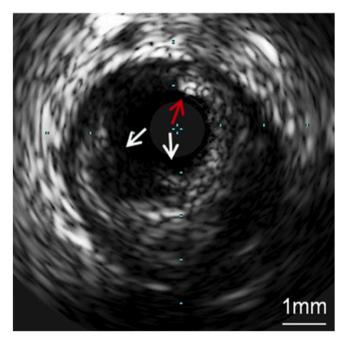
Plaque erosion visualized using high-definition intravascular ultrasound.
